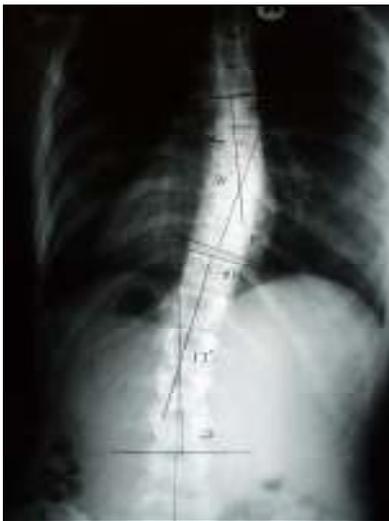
Baseline Anteroposterior Radiograph
